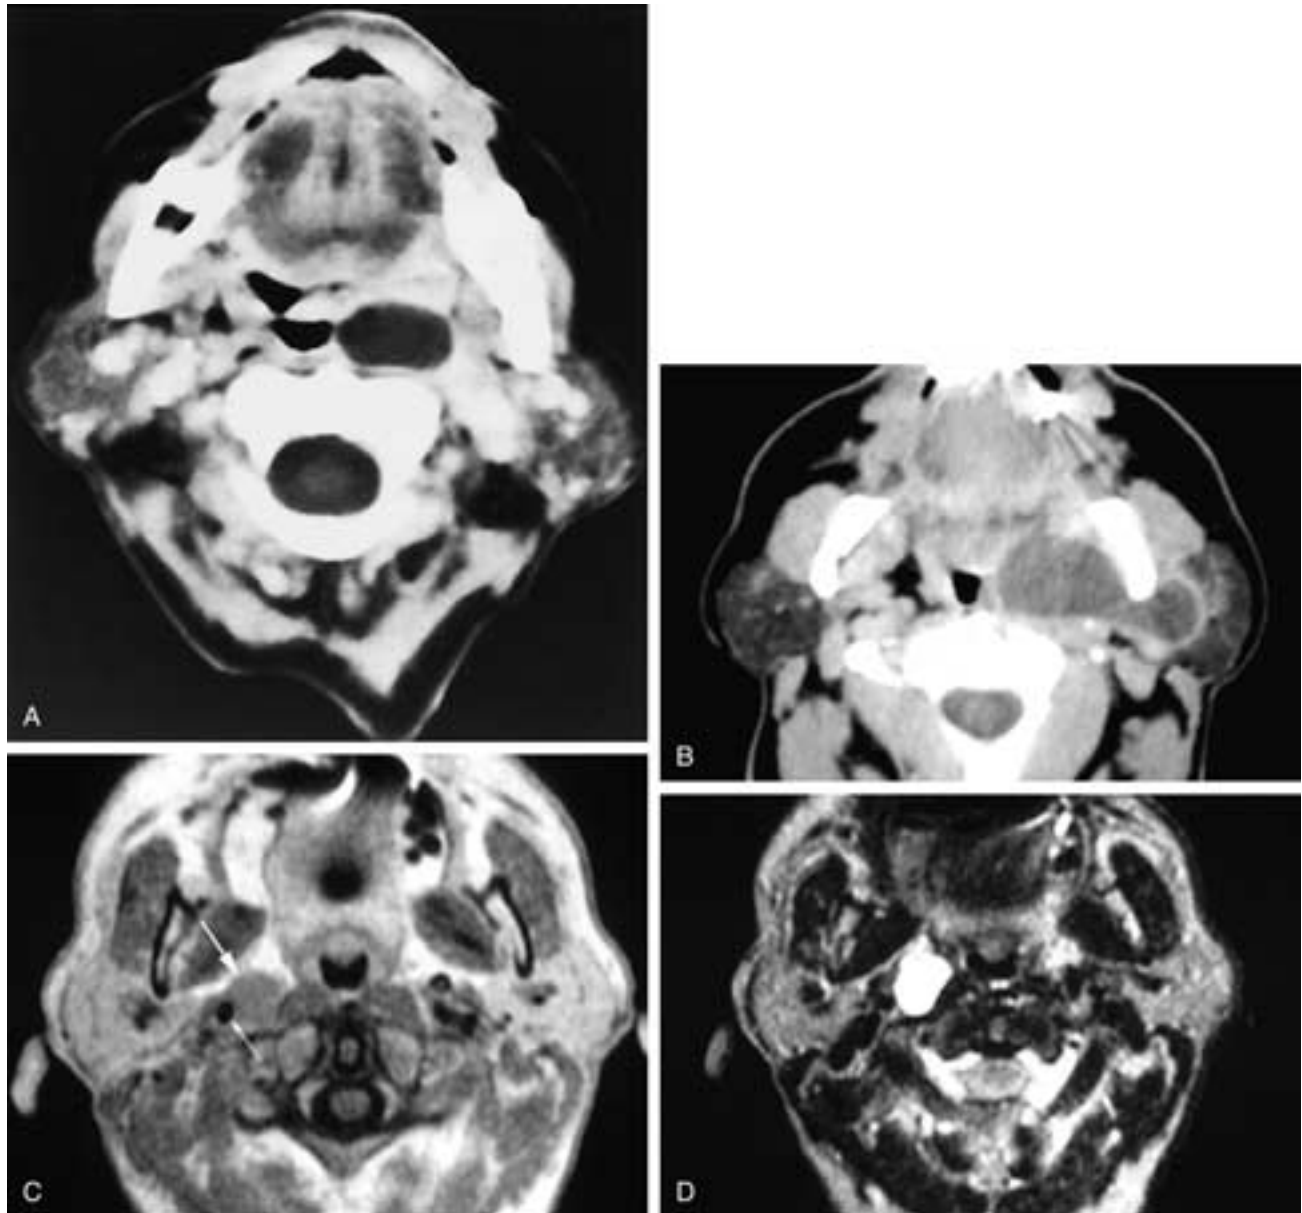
Axial contrast-enhanced CT scan (A) shows a smooth-walled cyst in the left parapharyngeal space. The cyst pushes the left pharyngeal wall toward the midline and is just anteromedial to the left carotid sheath. This was a branchial cyst. Axial CT scan (B) shows a dumbbell-shaped cyst in the deep portion of the left parotid gland and within the left parapharyngeal space. The narrowest portion of the cyst is at the level of the stylomandibular tunnel. This was a branchial cyst. Axial T1-weighted MR image (C) shows a small ovoid mass (*large arrow*) just anteromedial to the right carotid sheath and thus the ICA (*small arrow*). This branchial cyst had high T2-weighted signal intensity. Compare this image to Figure 38-15A, which shows a schwannoma within the carotid sheath. Axial T2-weighted MR image (D) shows a smooth-walled, high signal intensity ovoid lesion in the right parapharyngeal space lying immediately anteromedial to the carotid sheath. This is a slightly larger branchial cyst than that shown in C.
